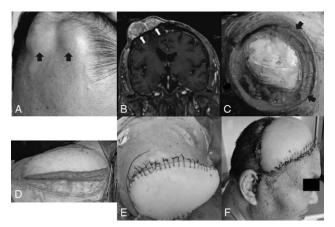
(A) Two prominent protuberances (black arrows) of the right frontal scalp were seen in the clinical image. (B) MRI showed the tumors were under the scalp (white arrows). (C) Scalp defect area (black arrows) after tumor resection. (D) The latissimus dorsi flap was used as donor flap. (E) The latissimus dorsi flap transplantation performed for right frontal plate coverage. (F) The wound healed well after 1-year follow-up.
